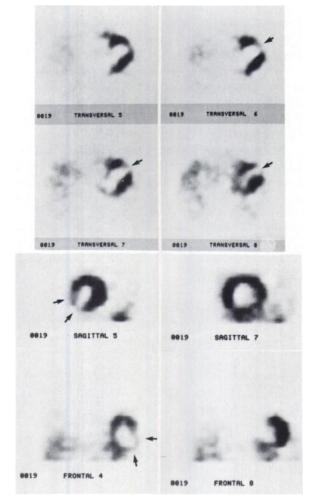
Transverse SPECT images (upper) of same patient, showing decreased uptake in apex and anterior wall (arrows). Findings confirmed in sagittal and frontal slices (lower, arrows).
